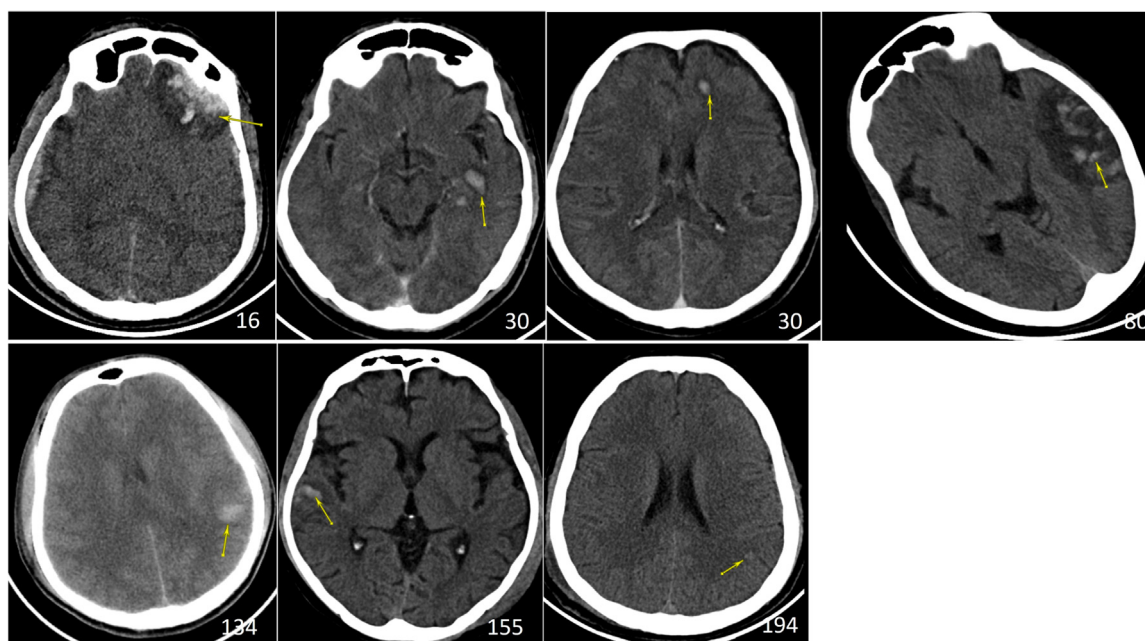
CT scan findings of locations of hematomas missed by NIRS device. The number indicates the chronological number of patients.
